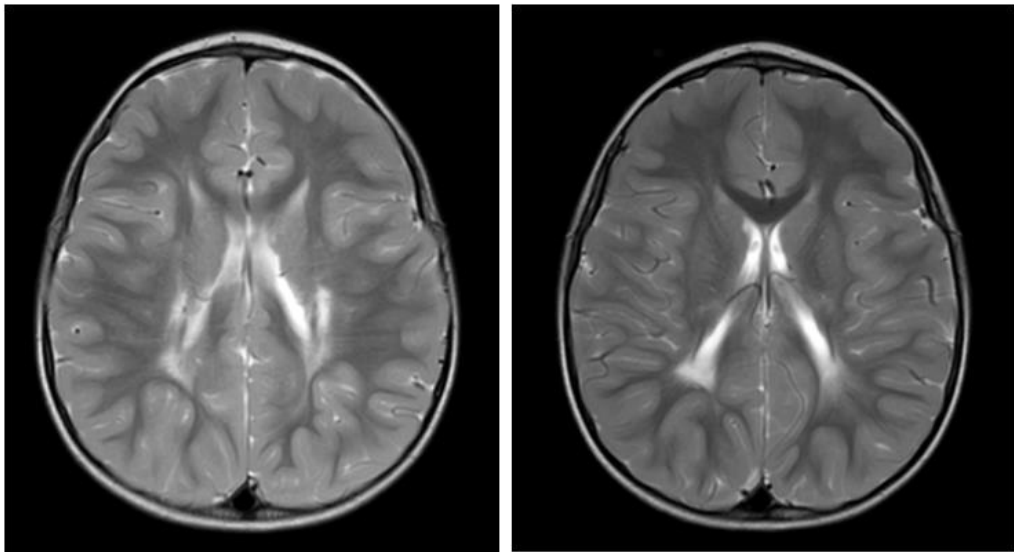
MRI brain of PHIV child (PID 51) showed periventricular leukomalacia
